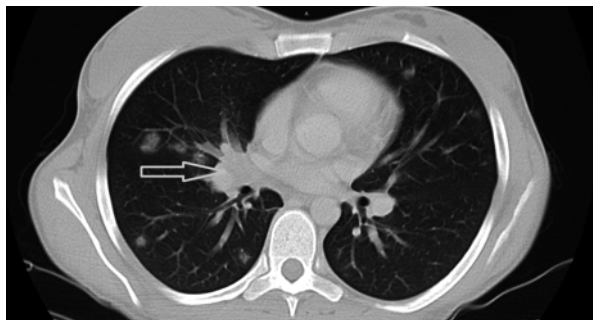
Computed tomography (CT) of the chest. Numerous focuses in the lung. Enlarged lymph nodes of the pulmonary hila
